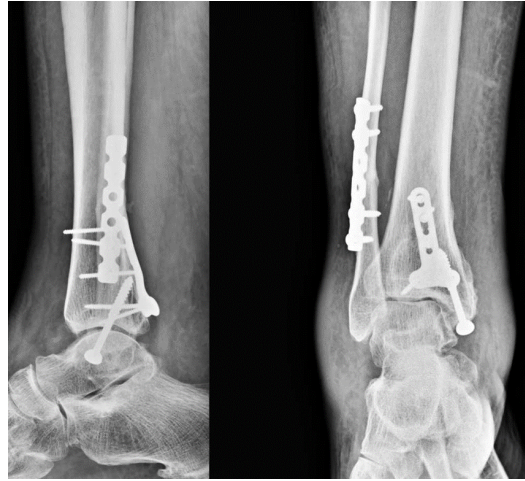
2 years post op x-ray showing excellent radiological healing of tri-malleolar fracture. There is no evidence of arthrosis or any evidence of syndesmotic separation.
